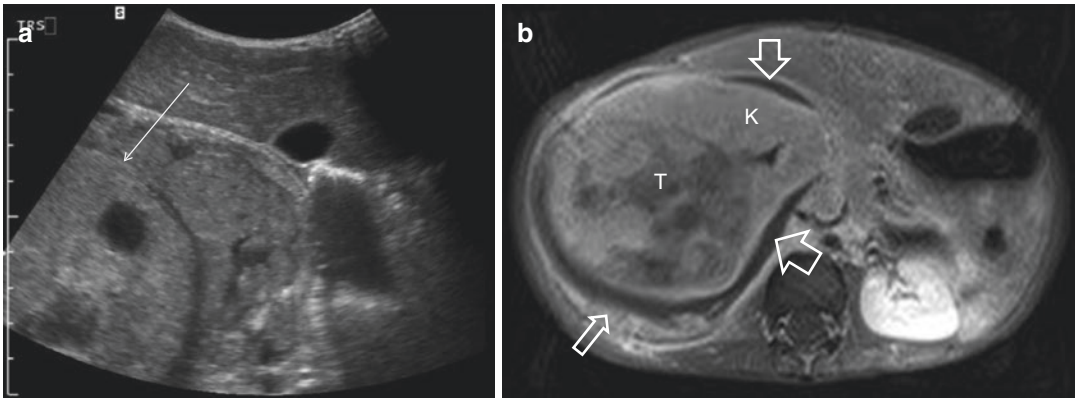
A 2-year-old girl presenting with abdominal pain and low hemoglobin levels. (a) US shows a solid intrarenal tumor. The tumor has invade the renal pseudo-capsule locally (*white arrow*) (b) MR imaging: T1 fat sat post-Gd shows a subcapsular hematoma (*open arrows*) surrounding
